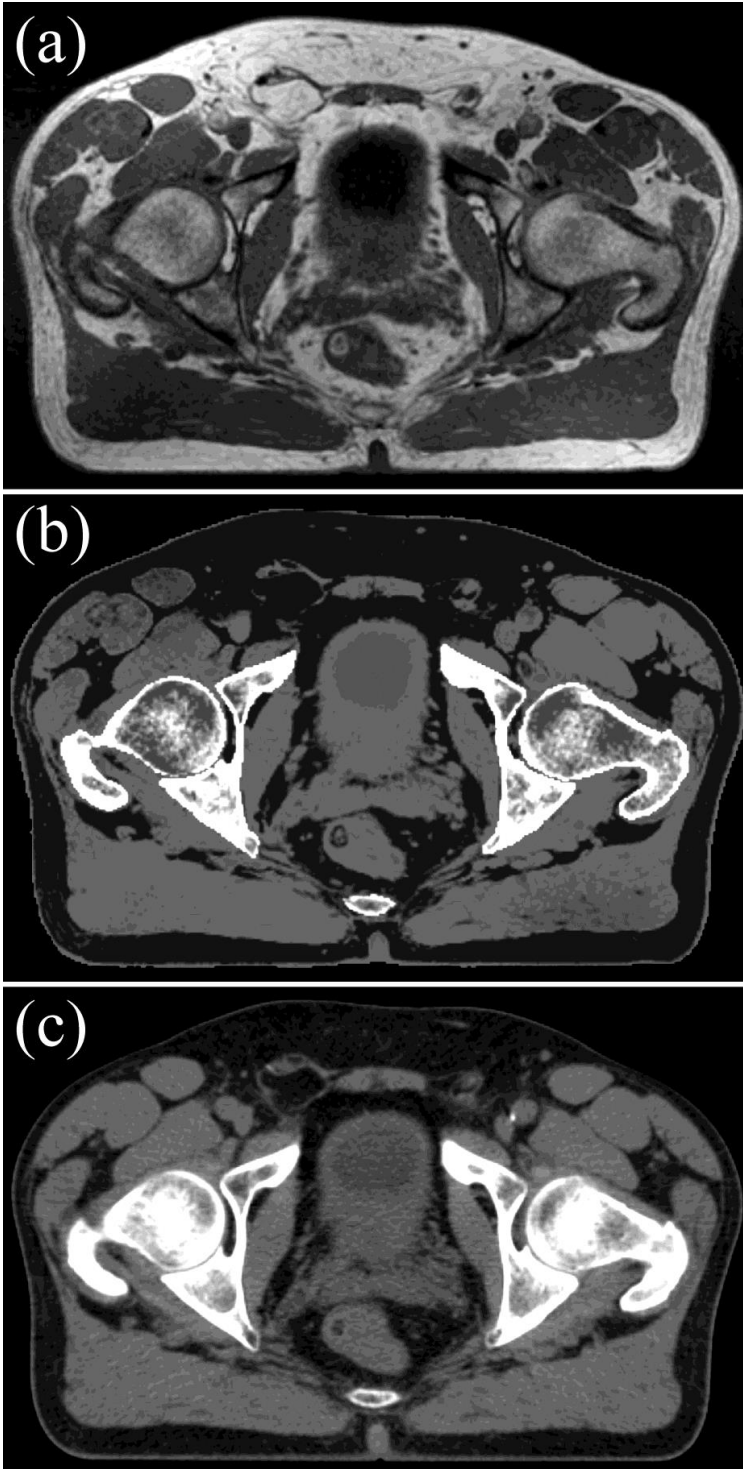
An example of a heterogeneous pseudo-CT (b) with the original MR image (a) from which the pseudo-CT was constructed by the dual model pseudo-HU conversion technique. The corresponding transversal slice of standard CT is shown in (c). Contrast in the images is not perfectly comparable (different windowing properties and scaling).
